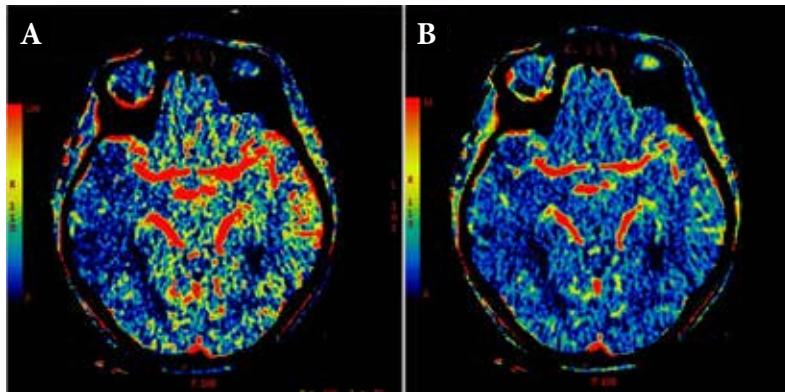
Brain CT perfusion showing a right frontal lobe zone of hypoperfusion and a core of infarction. A mismatch between the area of perfusion and the area of infarction was noted and predicted that the patient had benefit from mechanical thrombectomy. Left) Cerebral blood flow, indicating an area of poor perfusion. Right) Cerebral blood volume, indicating an area of infarction
